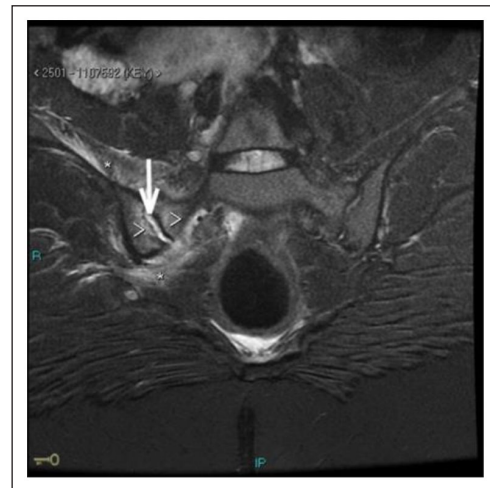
Pelvic MRI on admission showing bone marrow edema (arrowheads), small intraarticular fluid (arrow) and muscle edema-like change, myositis (asterisk).
